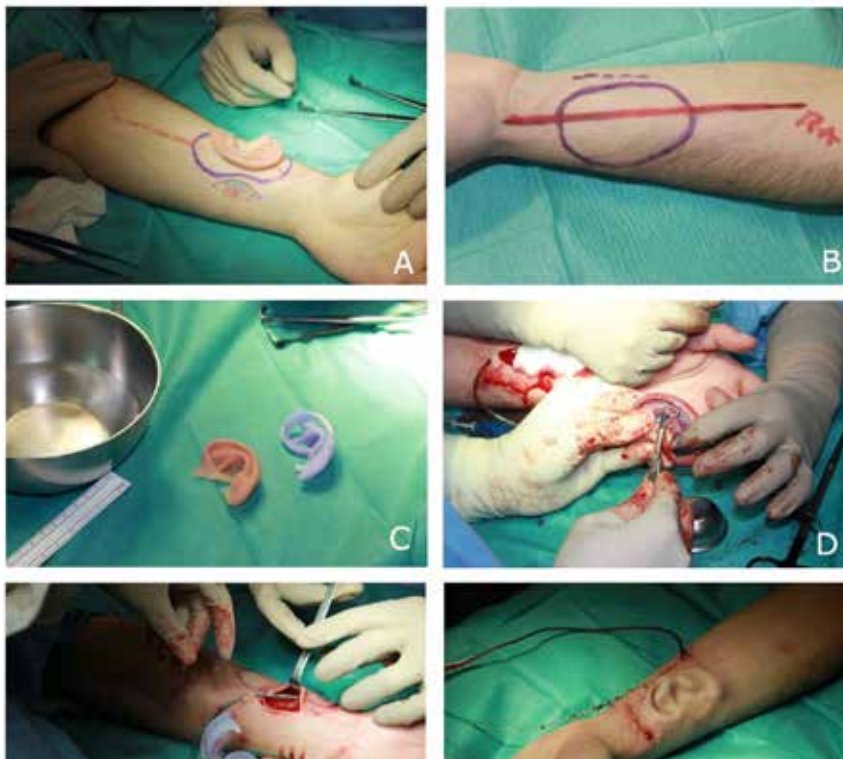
First surgery: (A) Flap markings. (B) Pocket planning. (C) A “printed” ear made of silicone based on the patient’s CT-scan of the contralateral ear was used for intraoperative comparison and molding of the future reconstruction. (D and E) The implant was trimmed to a desired shape and inserted into the pocket. (F) Immediate aspect after closure and placement of two suction drains
